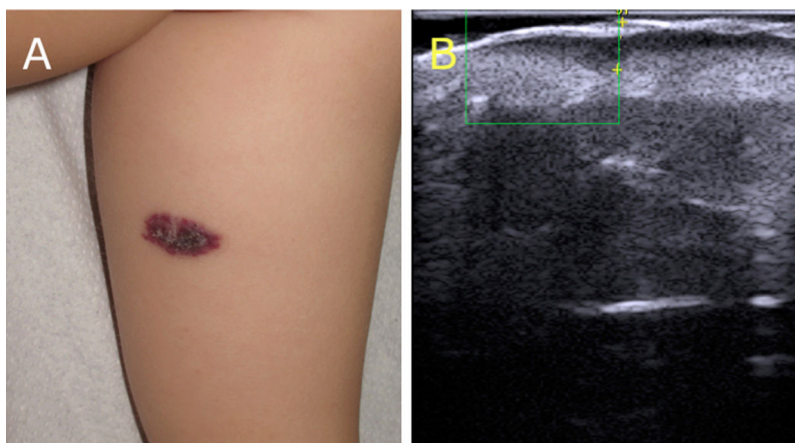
Clinical and ultrasound image of an angiokeratoma. A, Angiokeratoma circumscriptum. Erythematous plaque with a hyperkeratotic surface, clinically indistinguishable from verrucous venous malformation. B, Cutaneous ultrasound (22 MHz). Epidermal hyperechogenicity with vascular channels limited to the papillary dermis; no color Doppler signal.
